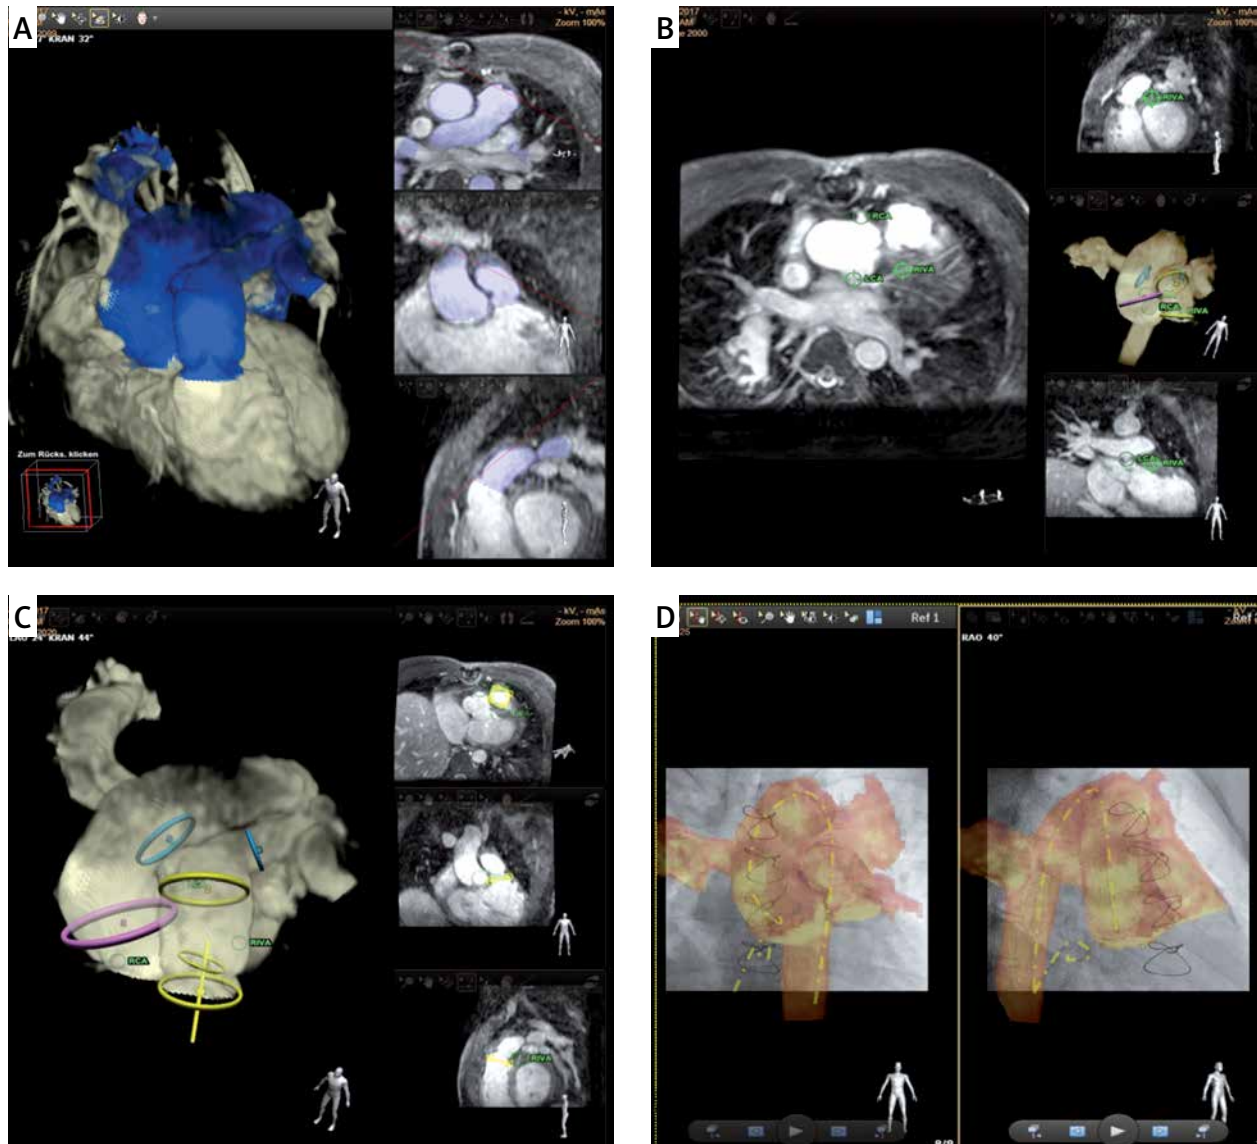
Percutaneous right ventricular outflow tract (RVOT) stenting and pulmonary valve implantation in 3-year-old male patient with pulmonary atresia (PA) and ventricular septal defect (VSD) with residual moderate stenosis and regurgitation of patch reconstructed RVOT. VesselNavigator assisted segmentation of magnetic resonance imaging 3D whole heart sequence without contrast (A). Green markers were placed to mark the right and left coronary artery (B). Additional yellow rings were placed to highlight the proximal, the narrowest and the distal part of the RVOT (C); origins of branch pulmonary arteries were marked with blue and the ascending aorta with a purple ring. Angiography and the position of two catheters placed in the aorta and the right atrium (yellow dotted line) were used for registration (D)
